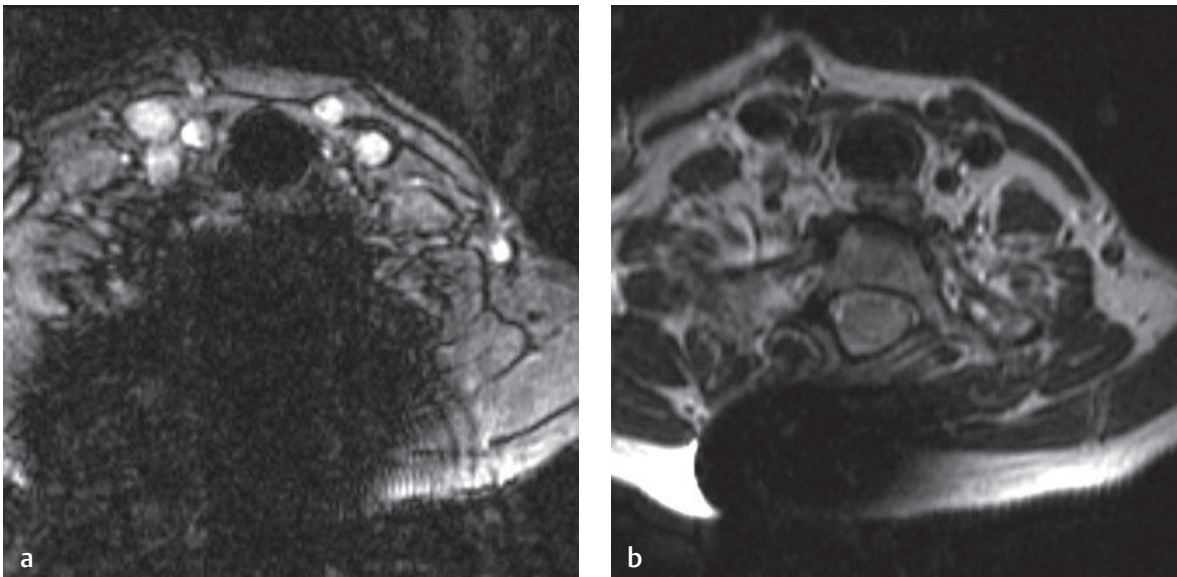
MRI in the presence of metallic implants. This patient had posterior spinal fixation at the T1 vertebral level. (a) An axial gradient-echo T2*-weighted image (a T2-like image [bright fluid] created with a gradient-echo rather than a SE technique) shows a large signal void obscuring the spinal canal. (b) An axial T2-weighted image with FSE/TSE technique at the same level in the same patient during the same imaging examination minimizes the susceptibility artifact from the metallic implants and substantially reduces the signal void so that the spinal canal contents are visible.[†]
